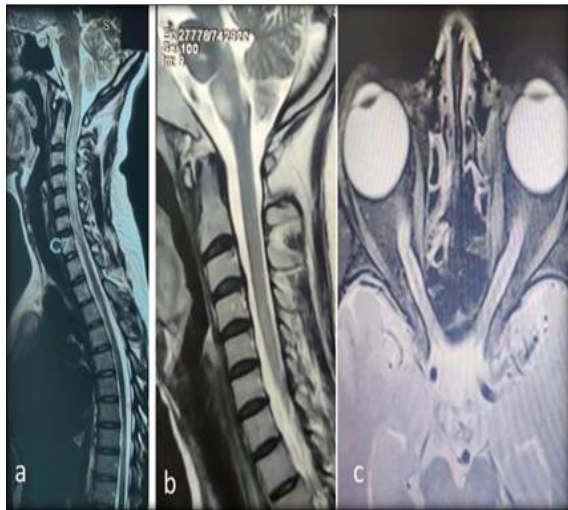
MRI cervical spine showing long segment transverse myelitis (a) up to C7 segments. T2 FLAIR hyperintensities are seen in lower brainstem (b). MRI orbit T2 FLAIR images showing bilateral optic nerve increased signal (c) in the intraconal segments seen in NMOAQP4 cases.
